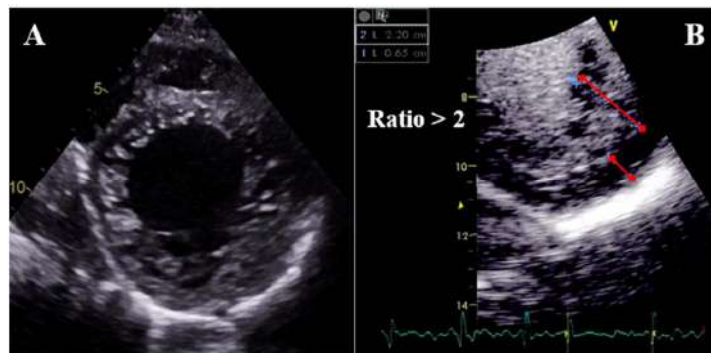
TTE parasternal short-axis mid-ventricular view of a patient with LVNC (A). Measurement of the compacted and non-compacted layers at end-diastole after echocontrast administration, fulfilling LVNC diagnostic criteria (B).
